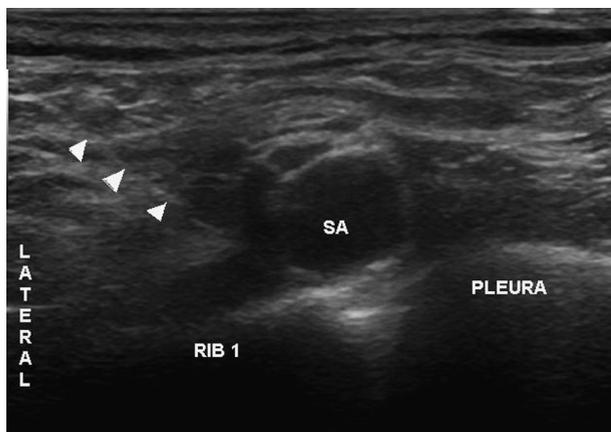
Ultrasound image of the brachial plexus in the supraclavicular area. Arrowheads show blocking needle. SA indicates subclavian artery; RIB 1, first rib.
